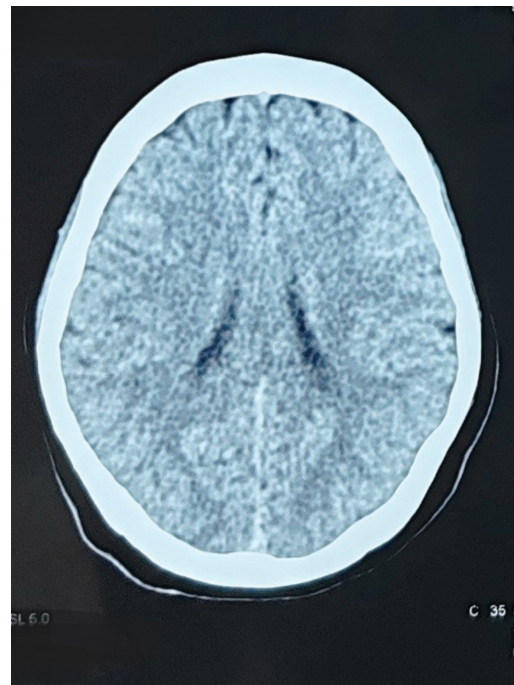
Non-contrast CT scan head (axial view) suggesting mild cerebral edema
